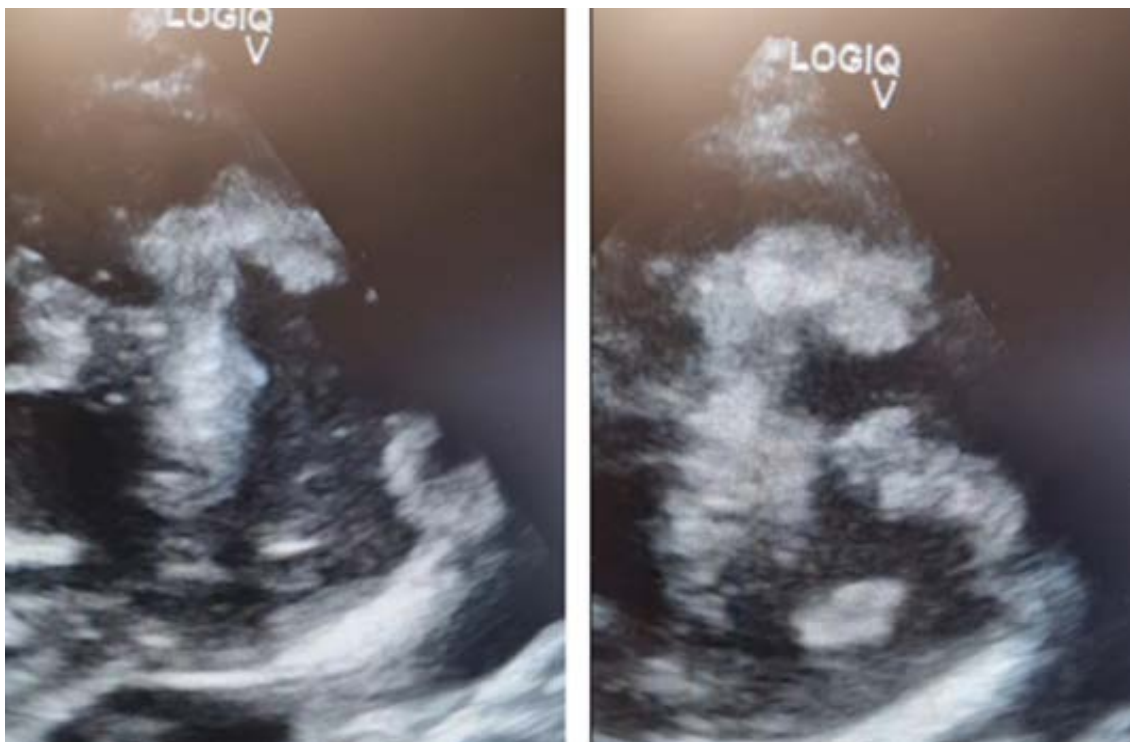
Transthoracic echocardiogram: A parasternal, short-axis view shows a mobile mass consistent with vegetation adjacent to the pulmonary valve.
